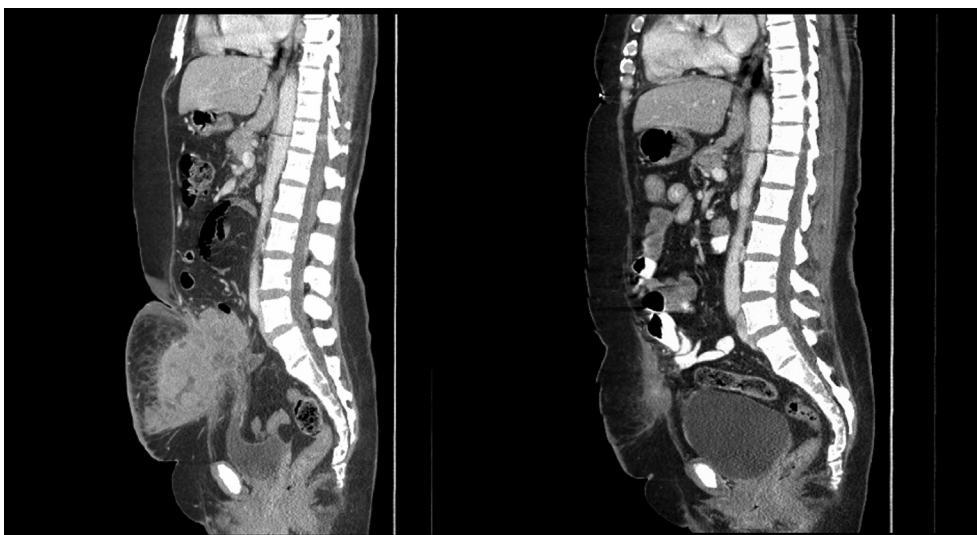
2a: CT image of patient at initial presentation. 2b: CT image of patient after three cycles of chemotherapy but prior to surgical resection.
